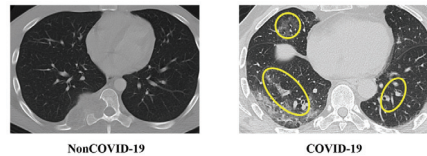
NonCOVID-19 및 COVID-19 폐 CT 이미지
